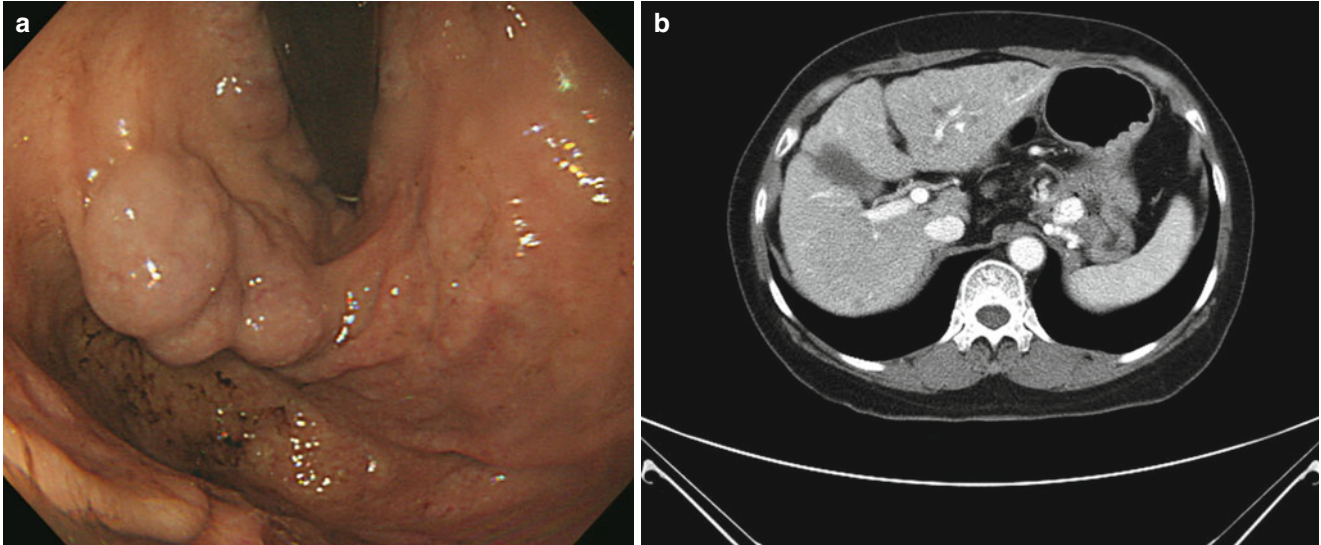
Gastric varix. (a) Endoscopic image of gastric varix presenting as thick serpiginous structures, covered by normal mucosa. (b) Abdominal CT scan showed marked dilatation of gastric varix
